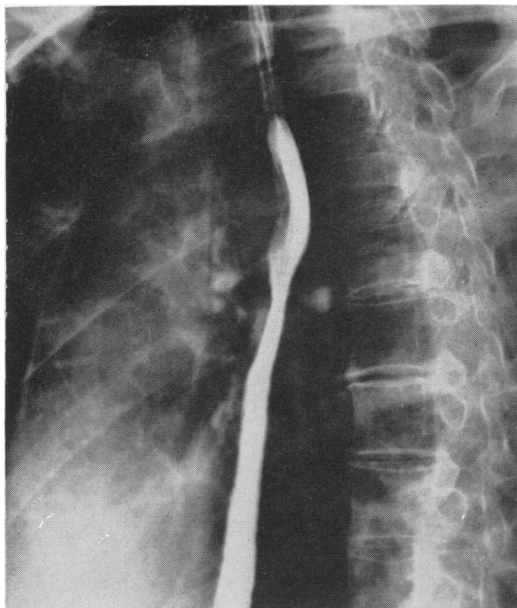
(Case 1). Oblique roentgenogram showing tumor in lower trachea.
